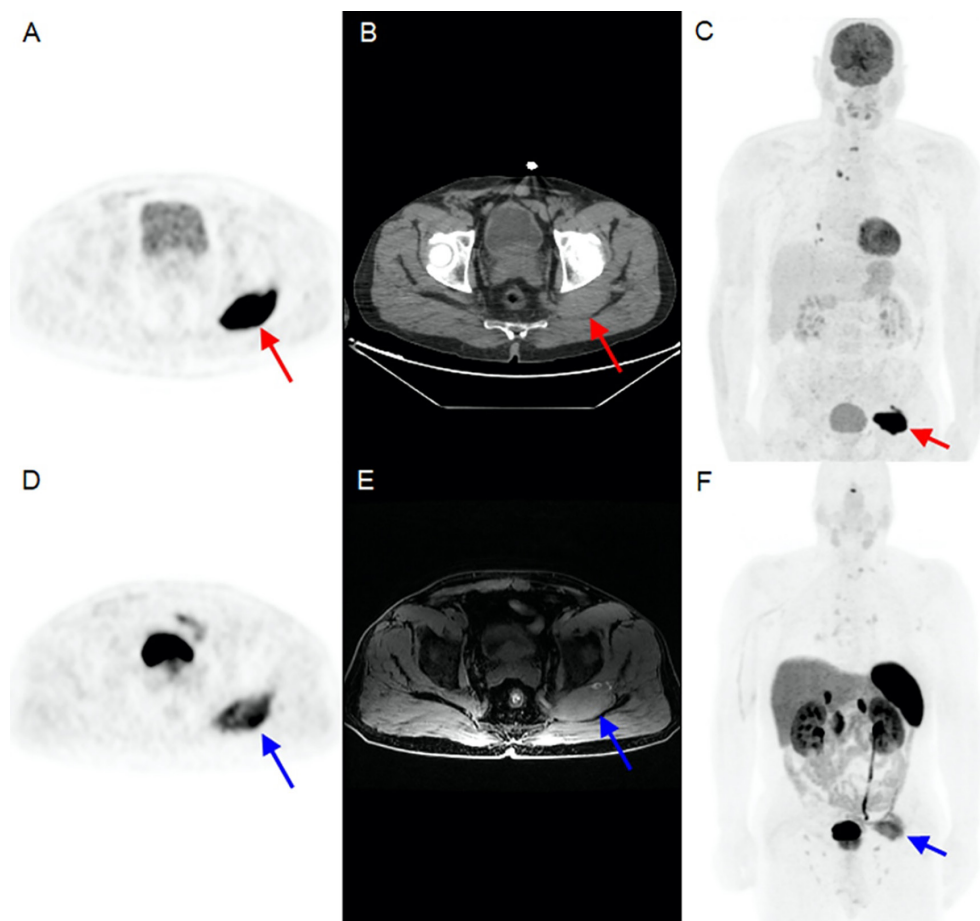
^{18}F -fluorodeoxyglucose-positron emission tomography (^{18}F -FDG PET) is beneficial in high-risk thyroid cancer patients who have increased thyroglobulin (Tg) levels (>10 ng/mL) for both metastasis detection and prognostication (1,2,3). ^{68}Ga -DOTATATE PET can also be performed for metastasis detection and for ^{177}Lu DOTATATE treatment planning (4,5,6). While cervical lymph nodes, lungs, and bones are the most common sites of metastasis, papillary thyroid carcinoma (PTC) can also metastasize to the brain, kidneys, liver, and adrenal glands (7). Skeletal muscle metastases are extremely rare (8). Our patient had a bilateral total thyroidectomy operation, and the pathology result revealed multicentric (R: 1.1, 0.3, 0.2 cm; L: 7 cm) PTC (follicular, oncocytic follicular, classical variants, and diffuse sclerosing variant containing tall cell areas) and 1/1 central lymph node metastasis. His post-operative stimulated Tg value was >500 ng/dL, and ^{18}F -FDG PET/computed tomography was performed to detect metastasis, which revealed cervical and mediastinal lymph nodes, and pulmonary metastases. Moreover, a $75 \times 36 \times 44$ mm hypermetabolic lesion was detected inside the left gluteal muscle [maximum standardized uptake value (SUV_{max})= 40.08]. After receiving a total of 750 mCi of radioactive iodine (RAI) therapy, the patient was considered RAI-refractory because of sustained high serum Tg levels. The gluteal lesion did not show radioiodine uptake. The patient underwent ^{68}Ga -DOTATATE PET for radionuclide therapy planning due to a state refractory to RAI. The gluteal lesion showed increased DOTATATE uptake ($73 \times 38 \times 40$ mm, SUV_{max} = 10.43), which increased suspicion for the lesion. A biopsy was performed to rule out a second primary malignancy, and it confirmed thyroid cancer metastasis. Besides being extremely rare, this is the first report of a ^{68}Ga -DOTATATE PET/magnetic resonance imaging (MRI) of thyroid cancer muscle metastasis, to our knowledge. ^{18}F -FDG PET (A), computed tomography (B), and maximum intensity projection (MIP) (C) images of the patient showed a well-circumscribed left gluteal lesion, which had an intense FDG uptake (red arrows). ^{68}Ga -DOTATATE PET (D), T1-weighted MRI (E), and MIP (F) images showed heterogeneously increased ^{68}Ga -DOTATATE uptake (blue arrows).
